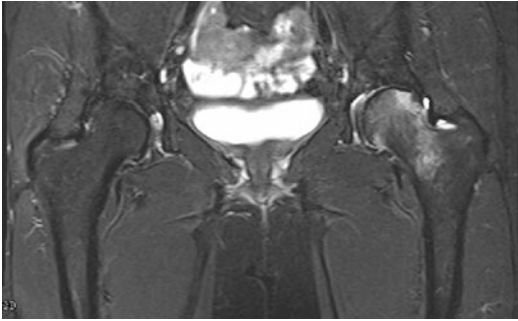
A 60-year-old female with hip pain, no history of trauma. Insufficiency fractures and bone bruise observed at proximal femur with MRI
